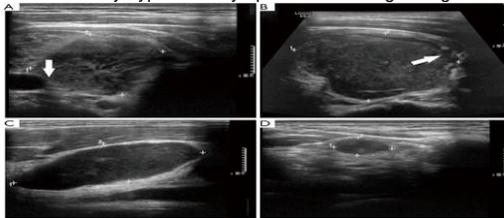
Transverse image of ultrasonography showed nodular type of PTL. There was an irregular-shaped hypoechoic mass in the right lobe of the thyroid. The lesion had invaded the vascular wall, 3b transverse image of ultrasonography showed a markedly hypoechoic mass in the left lobe of the thyroid with invasion of thyroid capsule. 3c, 3d longitudinal image showed pathologically confirmed involved lymph nodes in the left cervical III region appeared as markedly hypoechoic lymph nodes lacking echogenic hilum.<sup>40</sup>
